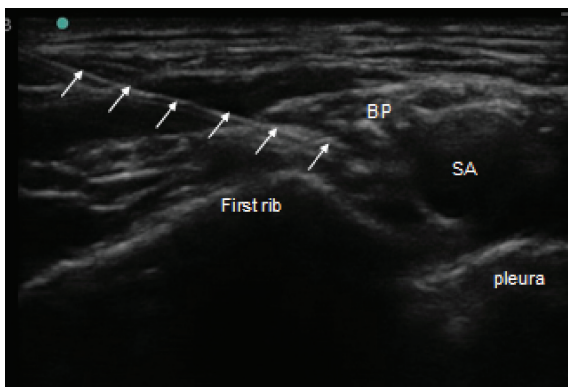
Sonographic image of needle advanced to the brachial plexus (arrow: needle, BP: brachial plexus, SA: subclavian artery).
